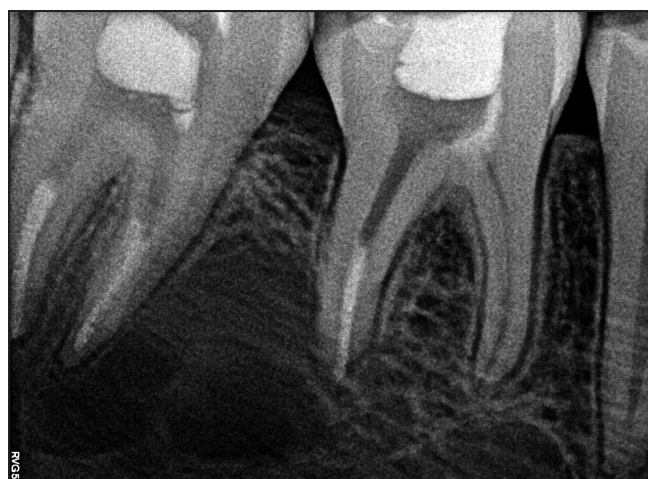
Operative dental radiograph of the right mandibular first molar.
